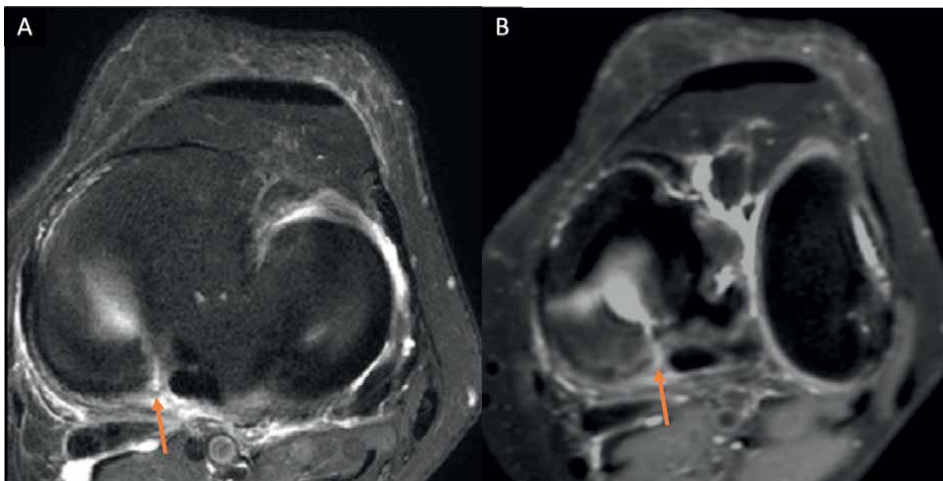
A 45-year-old female left knee. MRI were performed using a 3.0 T system with 2 mm thickness (A) PD FSE FS axial 2D image with suspected tear of posterior root of medial meniscus (arrow). (B) Multiplanar reformatted axial 3D VISTA (*volume isotropic turbo spin echo acquisition*) image of 0.5 mm slice thickness with better delineation of posterior root tear (arrow).
